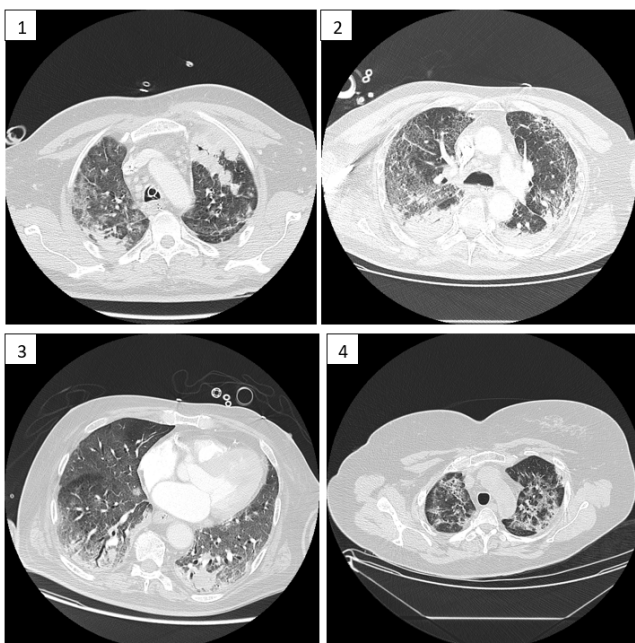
Patients´ Computed tomography Scans.
